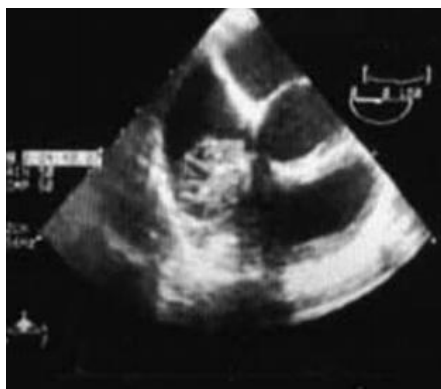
Transesophageal echocardiography. Multivesicular hydatid cyst on the lower part of the interatrial septum
